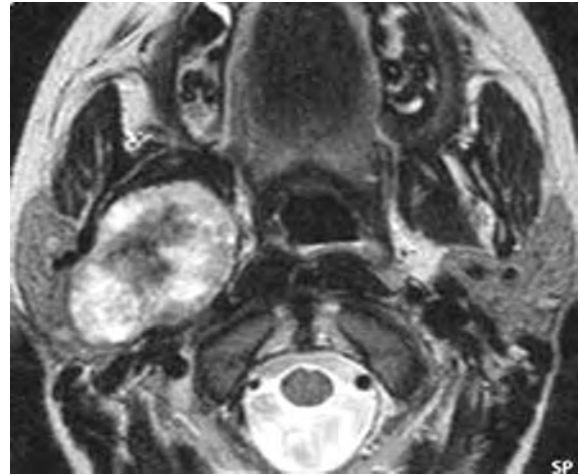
Large pleomorphic adenoma of the deep lobe of the right parotid gland with non-homogeneous, high-signal intensity on this T2-weighted image. Larger tumors typically show slightly heterogeneous signal intensity
